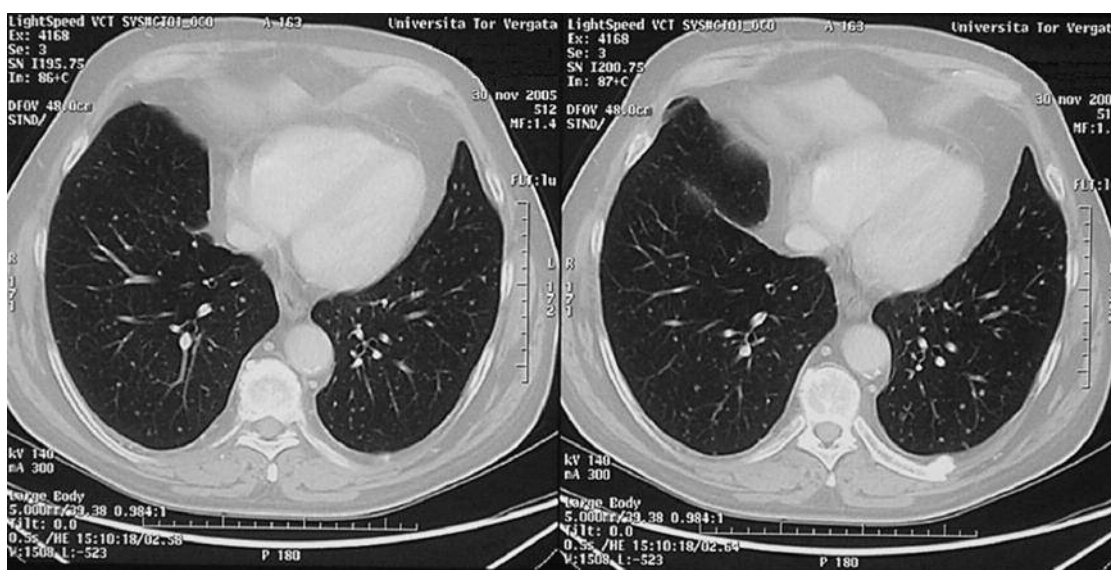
CT scan after 4 cycles of systemic immunotherapy showing the appearance of pulmonary secondary lesions.
